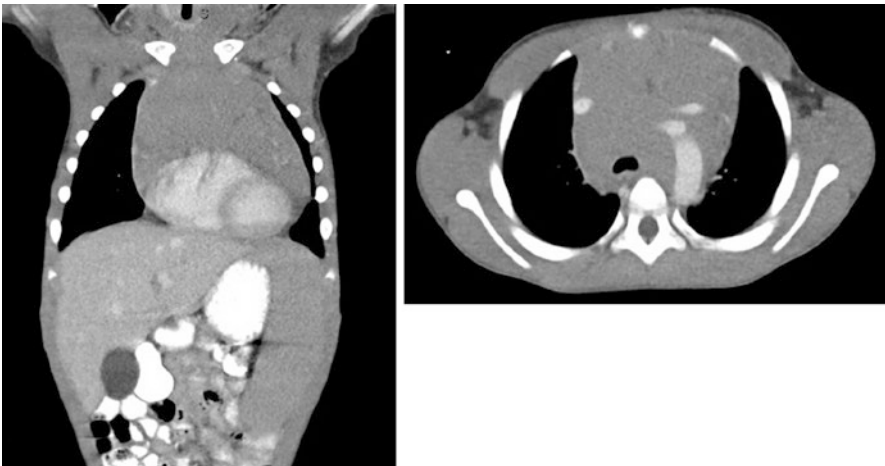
CT images of patient with T-cell ALL demonstrate a large anterior mediastinal mass measuring approximately 8.8 cm × 3.3 cm and causing narrowing and mass effect on the SVC, brachiocephalic veins, and trachea
